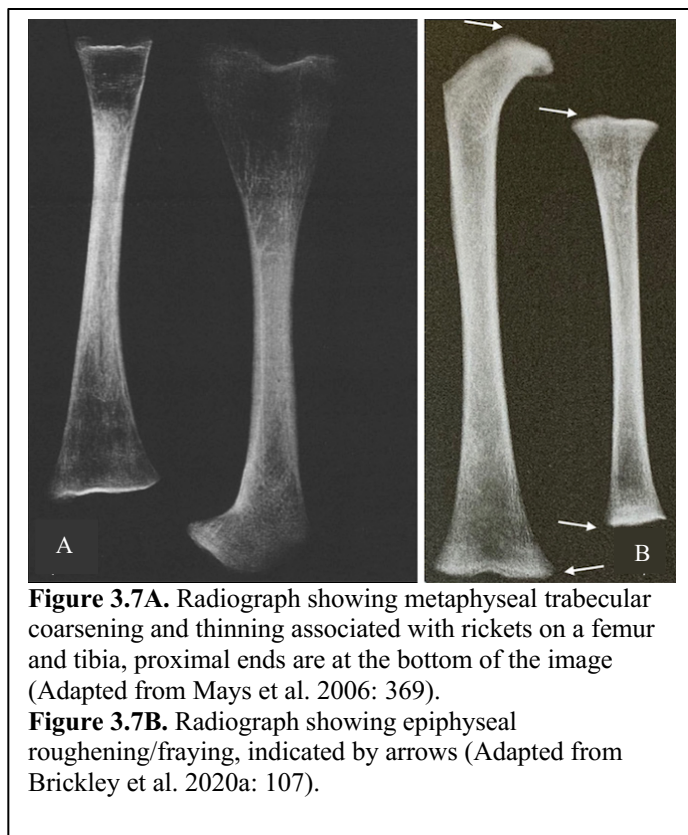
Radiograph showing metaphyseal trabecular coarsening and thinning associated with rickets on a femur and tibia, proximal ends are at the bottom of the image (Adapted from Mays et al. 2006: 369).
